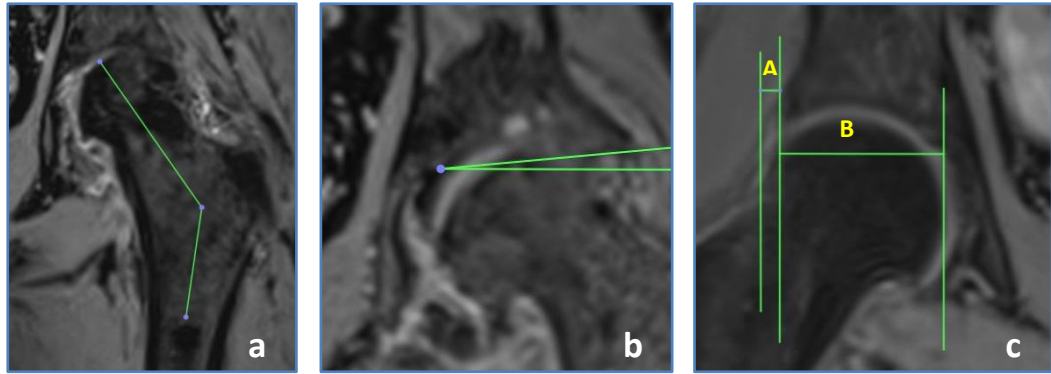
2D measurements taken at the level of the femoral head centre on the MRI SPACE sequence in the coronal plane using OsiriX. (a) femoral neck-shaft angle (FNSA); (b) acetabular index (AI); (c) femoral head extrusion index (FHEI).
